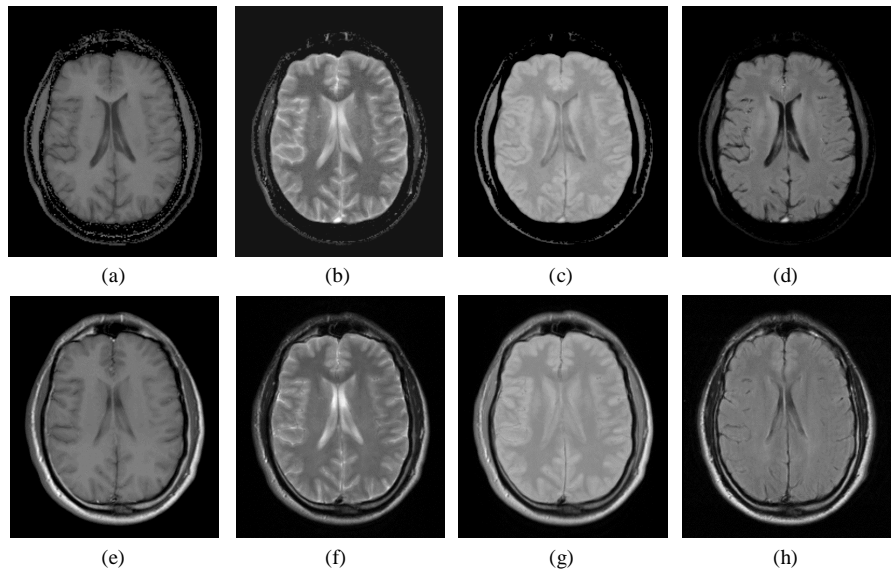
Synthetic (a) T_1 -weighted, (b) T_2 -weighted, (c) spin-density weighted, and (d) FLAIR contrast images calculated from a single IR True-FISP data set, compared to images with similar contrast information, obtained traditionally as four separate data sets (e-h).
